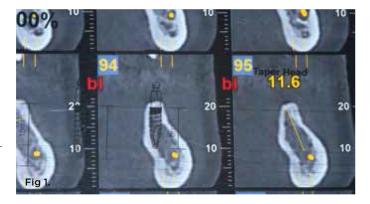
through Fig 3. CBCT with mini-implant overlay (1:1) (Fig 1); two MDIs in the No. 19 and 20 positions (Fig 2); panoramic radiograph showing cemented two-unit splinted PFM MISFR for Nos. 19 and 20 3.5 years after cementation of final restoration (Fig 3).
